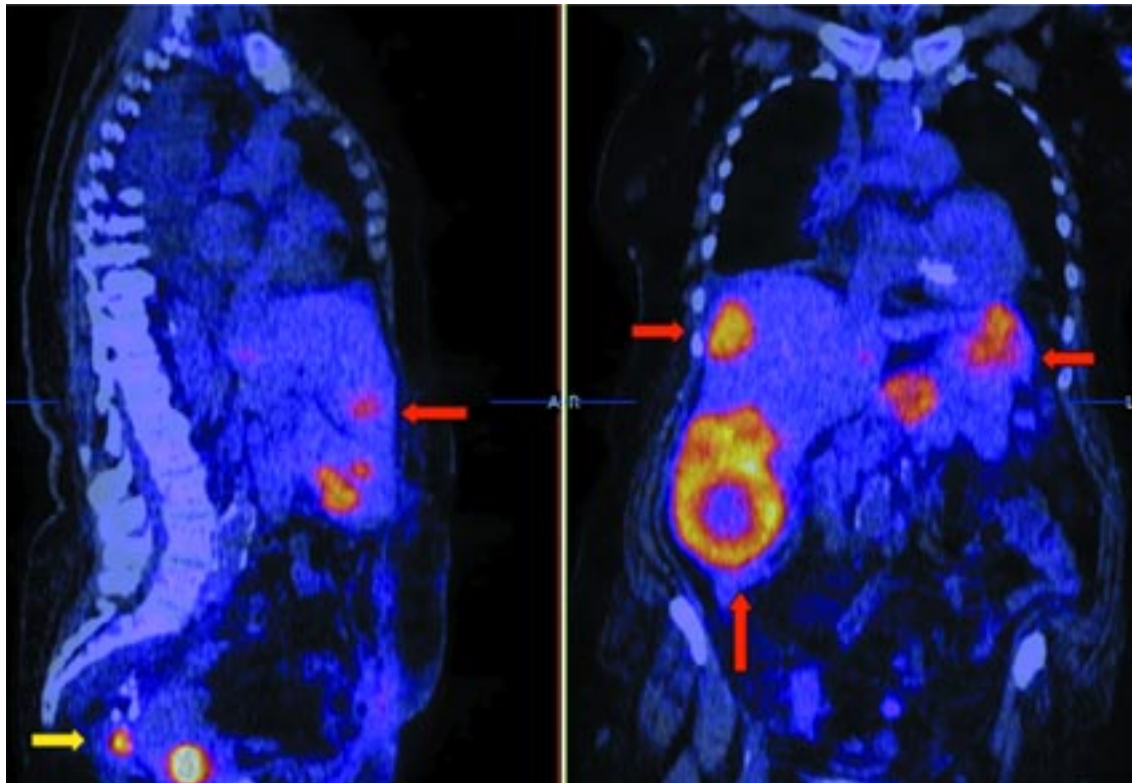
Sagittal (left) and coronal (right) PET/CT slices of patient with prior surgery and increasing carcinoembryonic antigen show increased FDG uptake in multiple liver lesions (red arrows), as well as recurrence of local disease in the presacral space (yellow arrow).
